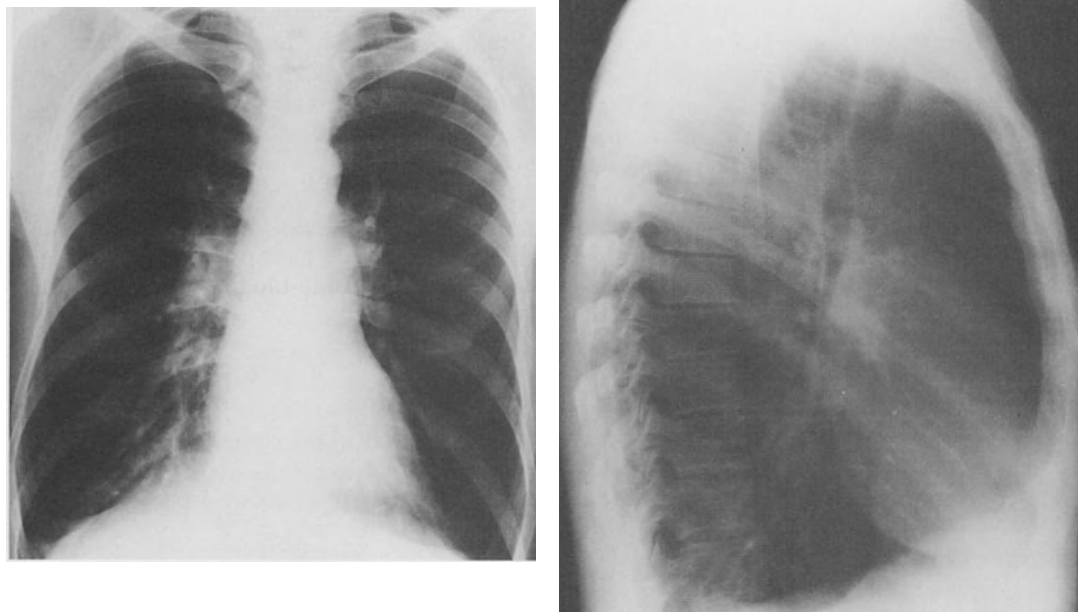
X-rays of the chest in chronic obstructive airways disease demonstrating hyperinflated translucent lungs, depressed diaphragms, and prominence of the main pulmonary artery.
